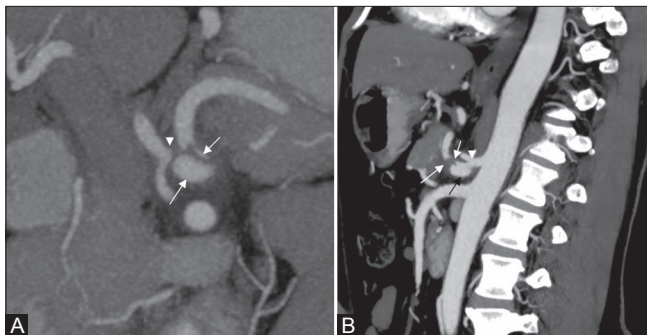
(A, B): Dissecting celiac artery aneurysm. (A) CT oblique coronal MIP image shows celiac aneurysm (large white arrow) with true lumen (small white arrow) and thrombosed false lumen (arrow head) occluding the proximal splenic, hepatic arteries. (B) Sagittal CT MIP image shows celiac aneurysm (black arrow) with compromised true lumen (small white arrow) and thrombosed false lumen (large white arrow). The left gastric origin (arrow head) is appreciated proximal to the aneurysm
